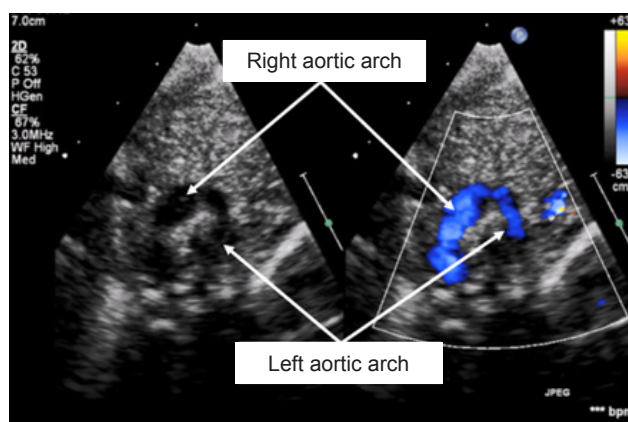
E-Trans thoracic echocardiogram - high parasternal view (2D and color flow mapping) showing the dominant right and the smaller left aortic arch.
